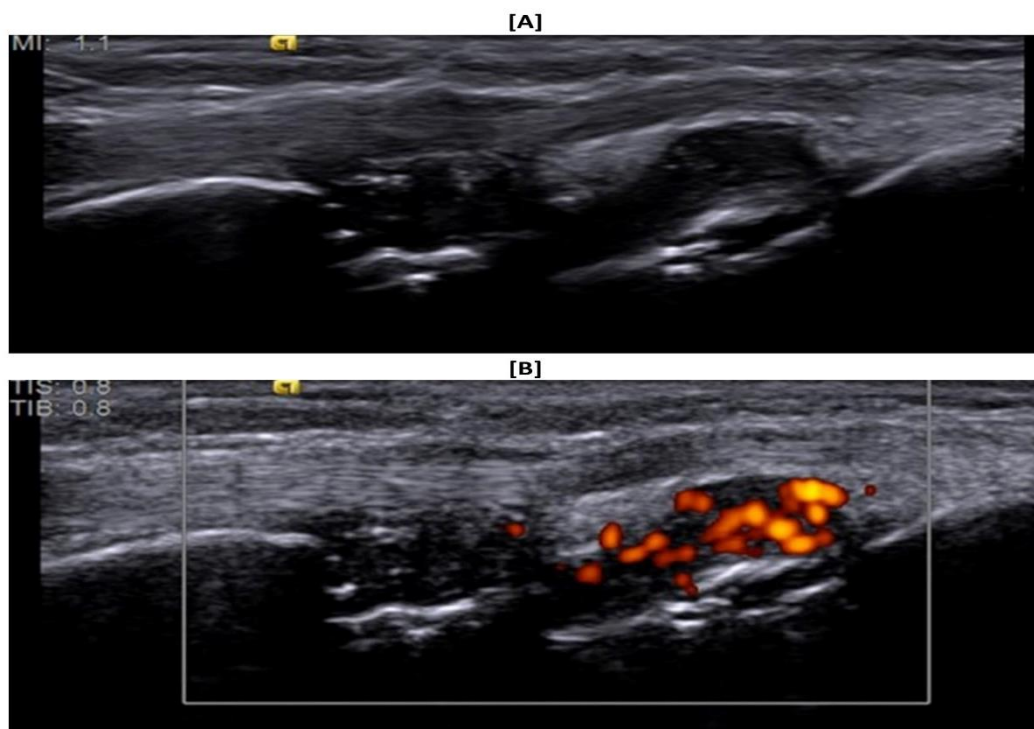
[A] Dorsal longitudinal scan of wrist joint showing grade 2 synovitis with grayscale [B] Dorsal longitudinal scan of wrist joint showing grade 2 synovitis with positive doppler signals.
